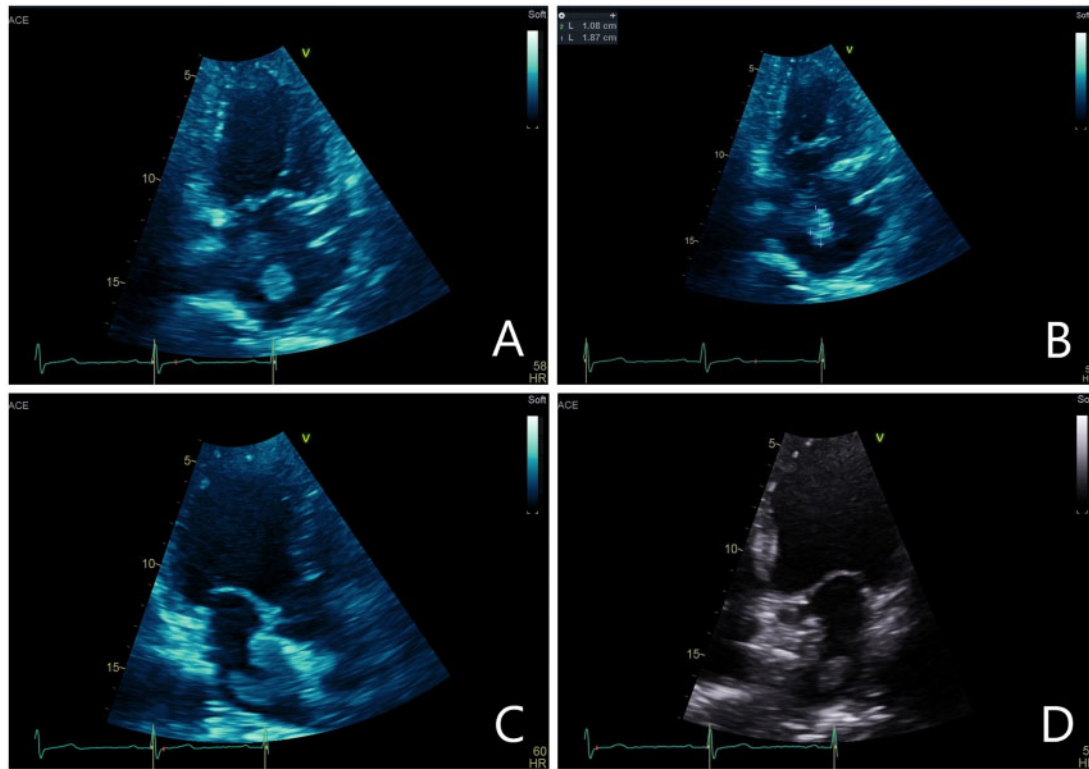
(A) Zoomed apical two-chamber view demonstrating 1.0 cm × 1.8 cm left atrial thrombus. (B) Apical two-chamber view demonstrating left atrial thrombus. (C) Apical three-chamber view demonstrating large left atrial thrombus adherent to patent foramen ovale-closure device. (D) Apical four-chamber view demonstrating mobile left atrial thrombus adjacent to patent foramen ovale-closure device.
